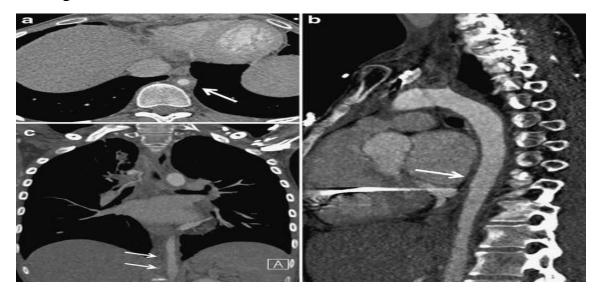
Computer tomography angiography in Takayasu arteritis: Axial (a), sagittal (b) and coronal (b) images of CTA of the torso demonstrate circumferential wall thickening.
